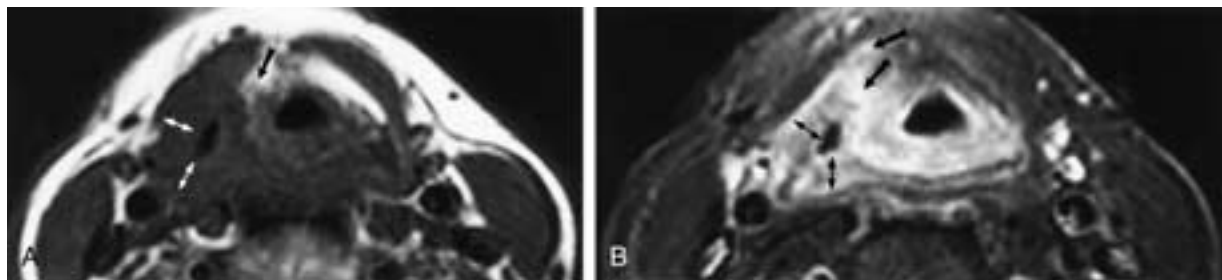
Pyriform sinus carcinoma—MR images. A, Axial T1-weighted image of a carcinoma infiltrating the right pyriform sinus (*double-headed arrows*) and the paraglottic (paralaryngeal) fat (*black arrow*). B, Axial T1-weighted image after gadolinium enhancement and fat suppression shows the pyriform sinus tumor (*double-headed arrows*). The anterior extent of the tumor is apparent (*single black arrows*), but the infiltration of the paraglottic fat is not seen well.
